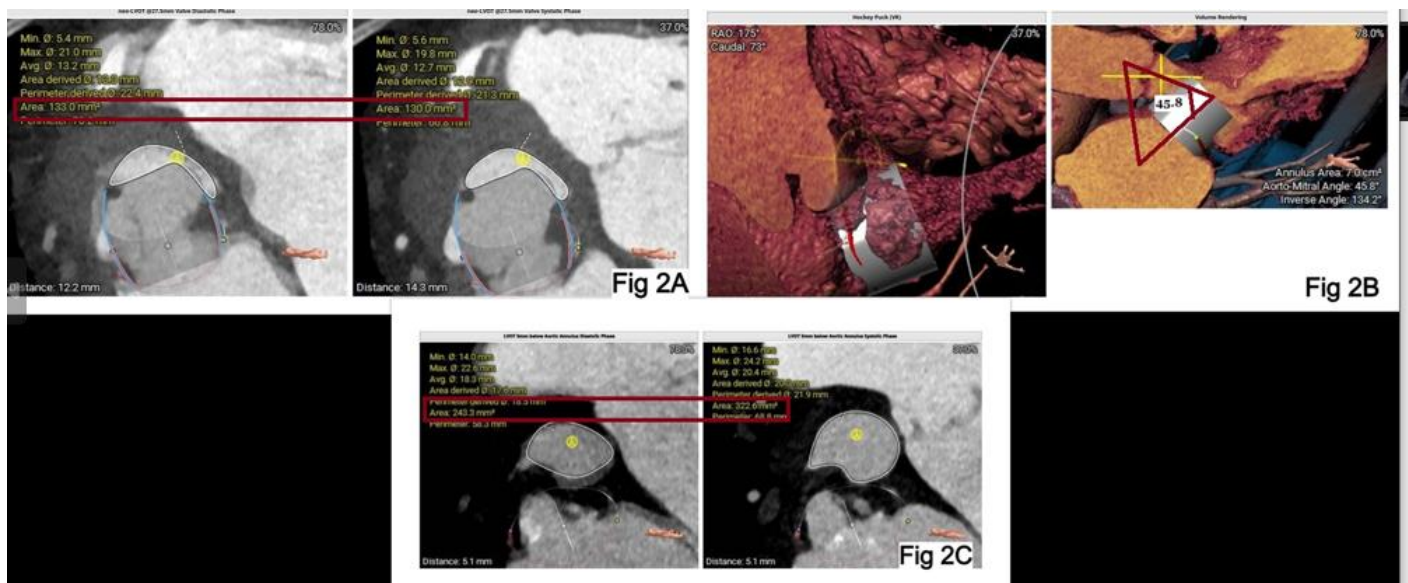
Dynamic computed tomography (CT) showing predicted neo-left ventricular outflow tract (LVOT) area of 130 mm² (Fig 2A), volume rendered CT showing unfavorable aortomitral angle (Fig 2B), and predicted neo-LVOT area after deployment of the valve (Fig 2C)
